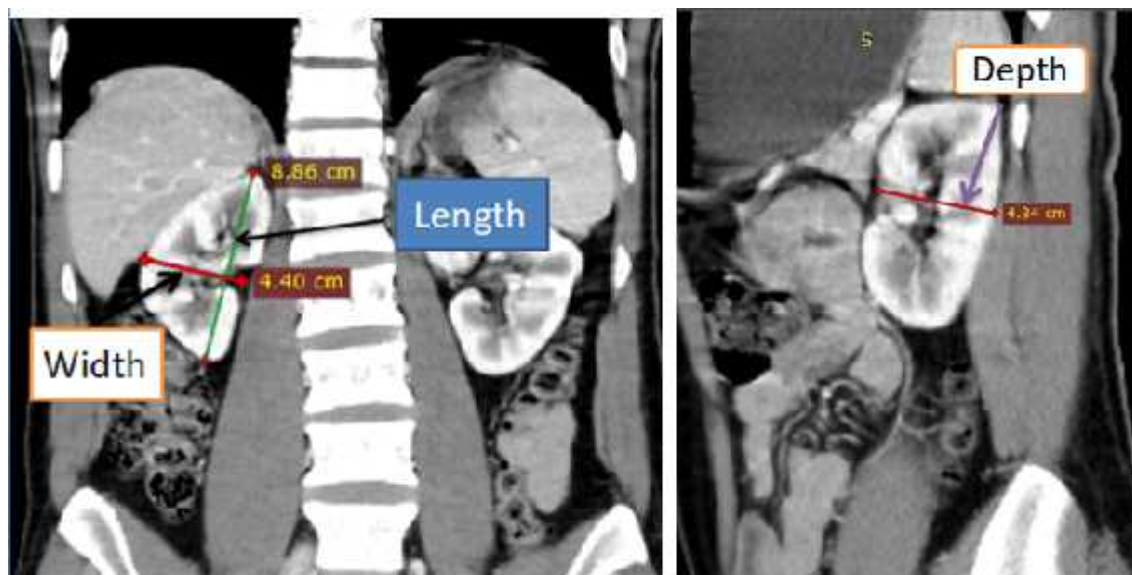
Abdominal CT scan, left coronal image showing length and width and right image s sagittal image showing depth or thickness of kidney
